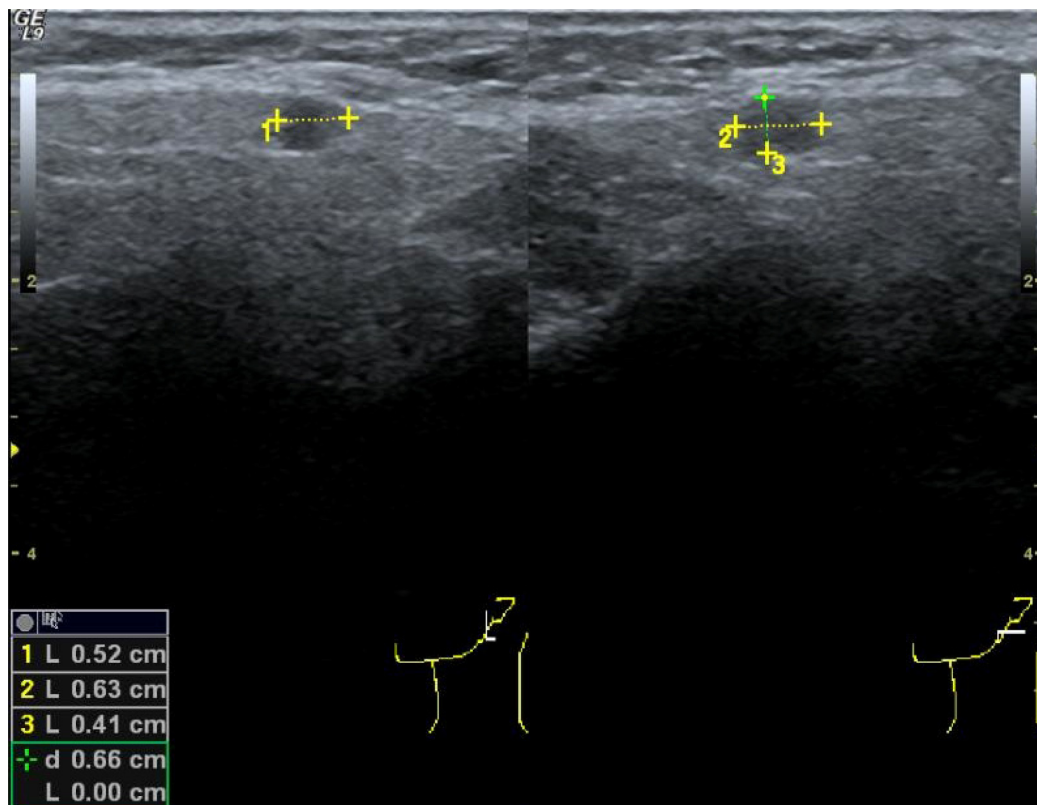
Ultrasonography imaging of the left parotid gland tumour.
